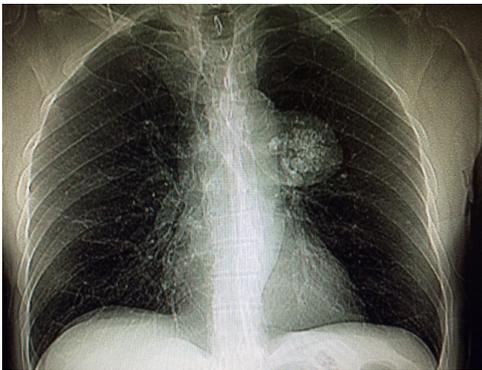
Chest x-ray shows a mass with calcification in the left upper lung field.
